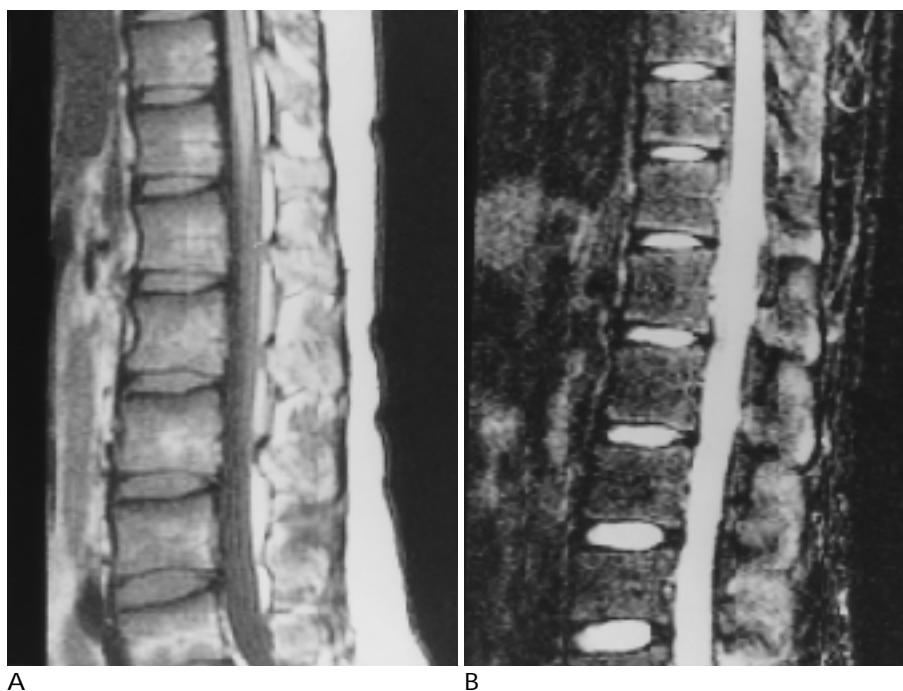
A 24-year-old man(patient No.3) with successful engraftment after allogeneic transplantation for severe aplastic anemia. Signal intensity of bone marrow is low to slightly high on sagittal T1-weighted image(A, 560/30)of the lumbar spine, and iso to low on STIR image(B, 1,400/30/120).
